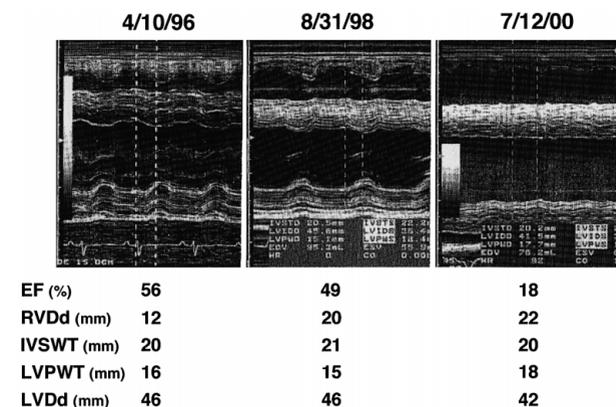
M-mode echocardiography over 5 years of follow-up shows a gradual decrease in the wall motion of both ventricles, and an increase in the chamber size of the right, but not the left ventricle. EF, ejection fraction; RVDd, right ventricular diastolic dimension; IVSWT, interventricular septum wall thickness; LVPWT, left ventricular posterior wall thickness; LVDd, left ventricular diastolic dimension.
